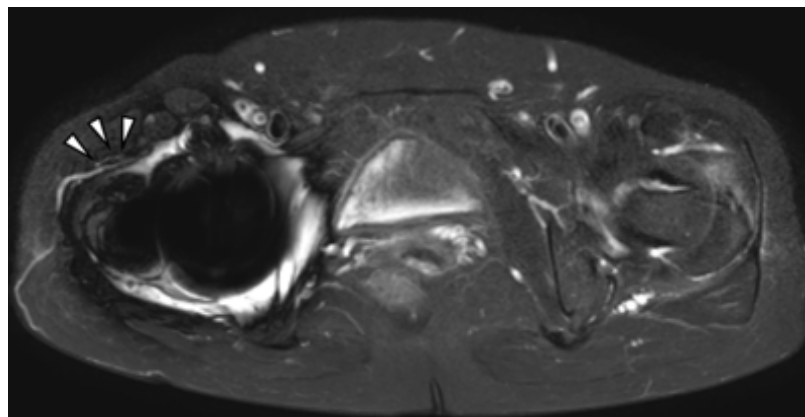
Magnetic resonance imaging obtained at the initial visit. A high-signal intensity area distinct from metal artifact is observed around the right hip joint (arrowhead), suggesting abscess formation.
